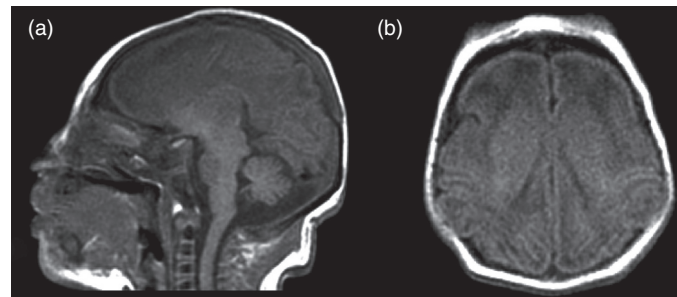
Microlissencephaly: neonatal (a) sagittal and (b) axial T1 MRI, showing microcephaly with agyric cortex.
